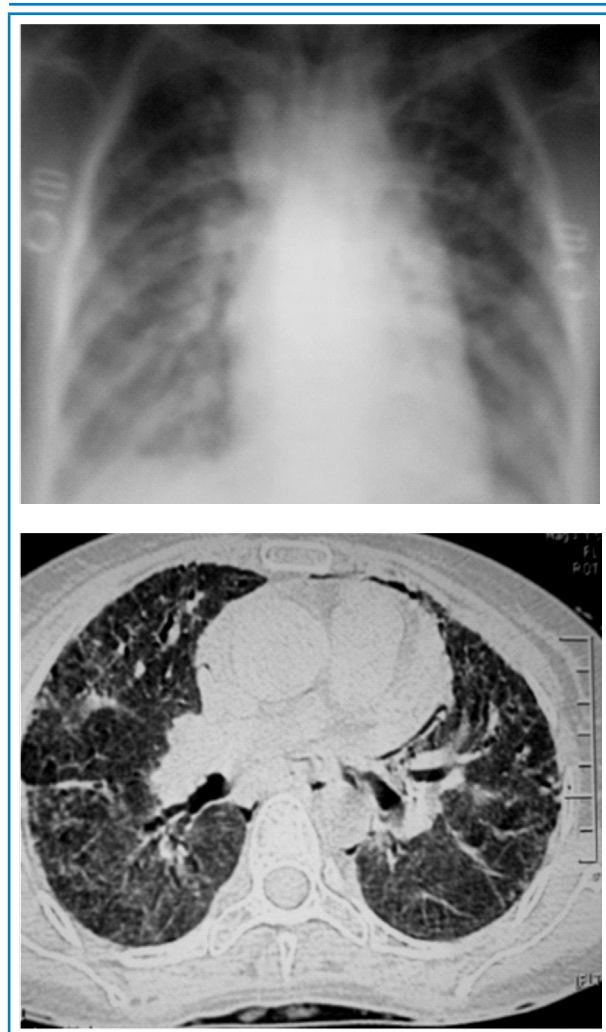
X rays film and CT scan film of patient.
